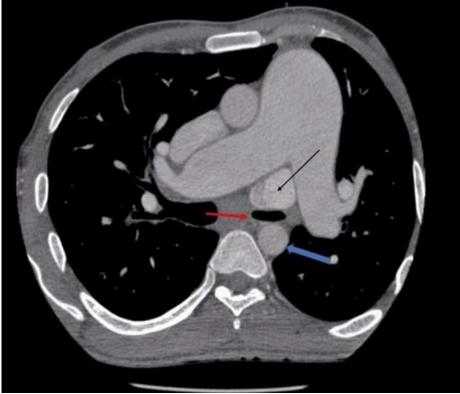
Axial Non-enhanced CT thorax at the level of bifurcation ofpulmonary artery and trachea The trachea can be seen compressed (red arrow) between the vertical vein (black arrow) anteriorly and aorta (blue arrow) posteriorly. This could be one of the factor contributing to difficulty in breathing.
